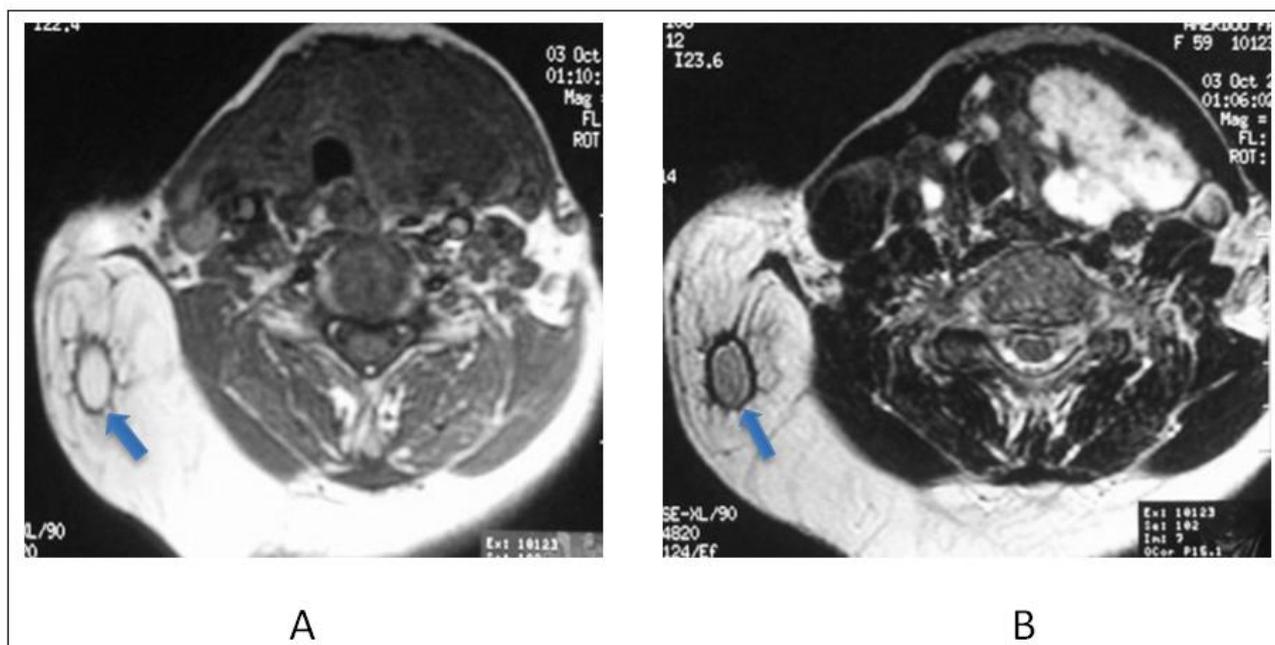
Axial T1-weighted (A), Axial 2-weighted (B) images showed well circumscribed tumor located beneath the right SCM muscle with high signal intensities (arrow). Inside the tumor, there were multiple thickened septa
